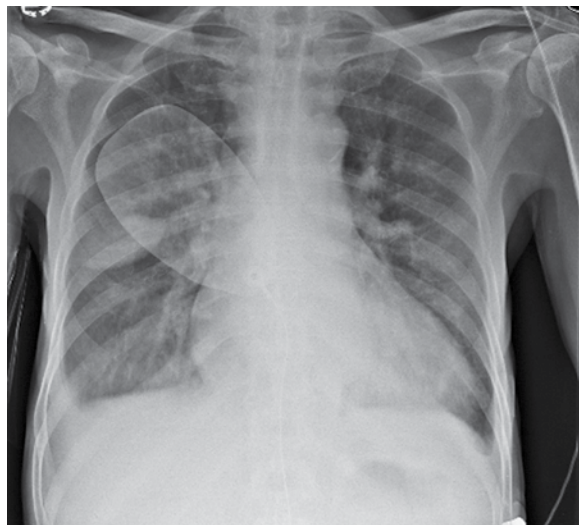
Chest x-ray showing pulmonary oedema and small bilateral pleural effusions. A defibrillator pad is present on the right chest wall.
